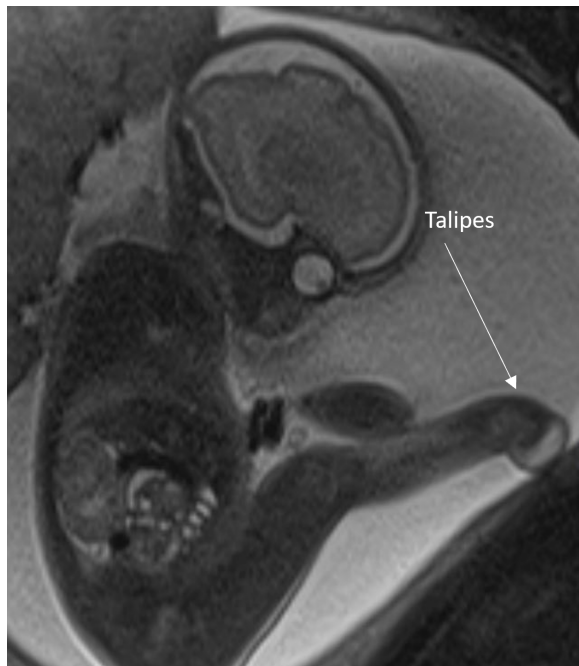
T2 HASTE STIR Sagittal MRI image of talipes in 29+6 week fetus
